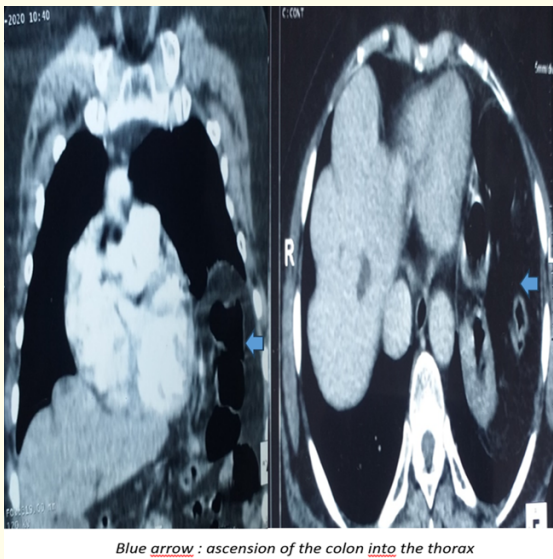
CT image of diaphragmatic hernia with digestive contents in our patient 1.
